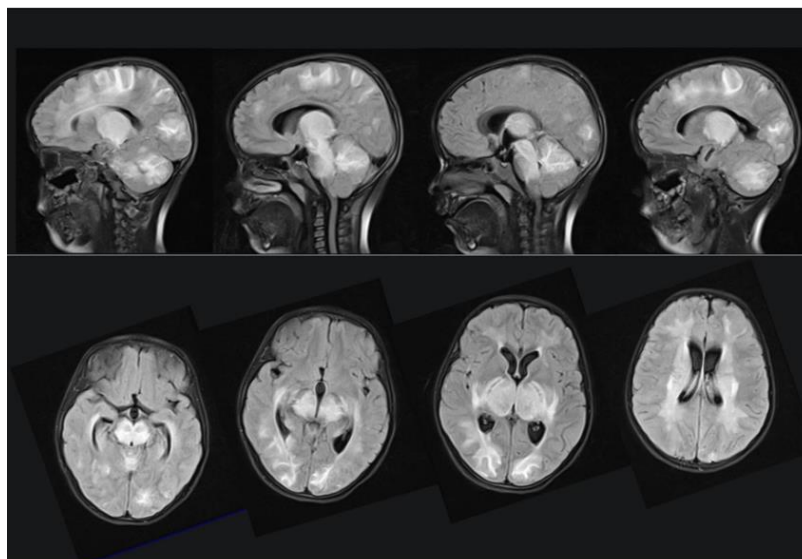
Axial and Sagittal T1 /T2W, FLAIR, and DWI MRI brain images (A, B) show increased signal intensity in bilateral subcortical white matter, posterior aspect of basal ganglia, thalamus, brain stem, and bilateral cerebellar white matter
